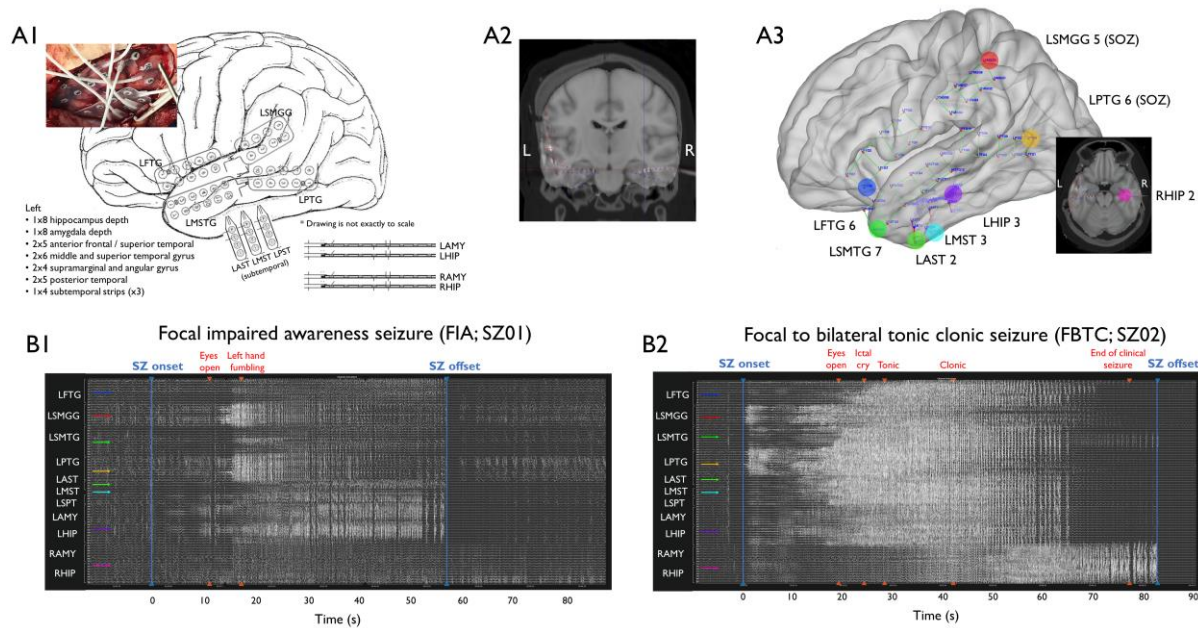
Exemplar 3D localization of intracranial electrodes (A) and iEEG signal for one FIA and one FBTC seizures (B) originating from a representative patient. (A) The surgical implantation and clinical electrode map (A1) are used to locate electrodes positions in the post-implantation CT and pre-implantation MRI images, aligned in MNI standard space using the iElectrodes software (A2); eventually, final electrodes localizations are displayed on a standard MRI template (A3). (B) Time courses of raw iEEG signals for a FIA (B1) and a FBTC (B2) seizure, along with marked behavioral events. Arrow colors indicate the colored electrodes displayed in A3. Contacts LSMGG 5 (in red) and LPTG 6 (in orange) were identified as belonging to the SOZ.
